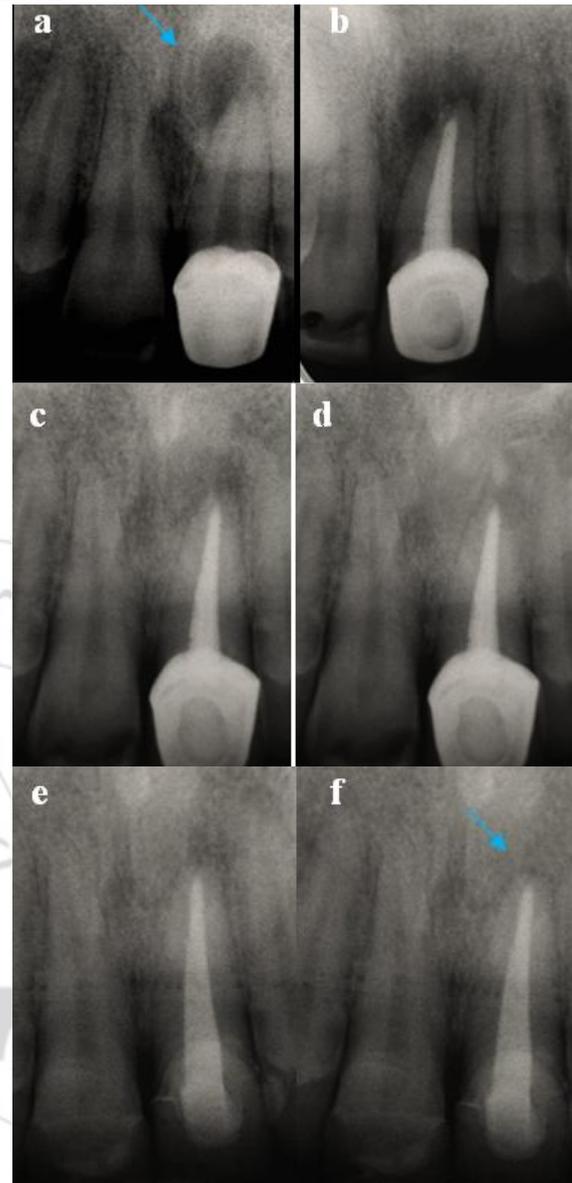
a/initial x-ray presents the periapical condition of tooth 21 indicated for primary endodontic treatment; b/definitive obturation of root canal using apical barrier from biphasic calcium phosphate ceramic and after that sealer and gutta-percha; c/control x-ray at the 3rd month; d/control x-ray at the 6th month and after that the old metal-ceramic crown were replaced with new one; e/x-ray after 1 year; f/x-ray after 4 years.
